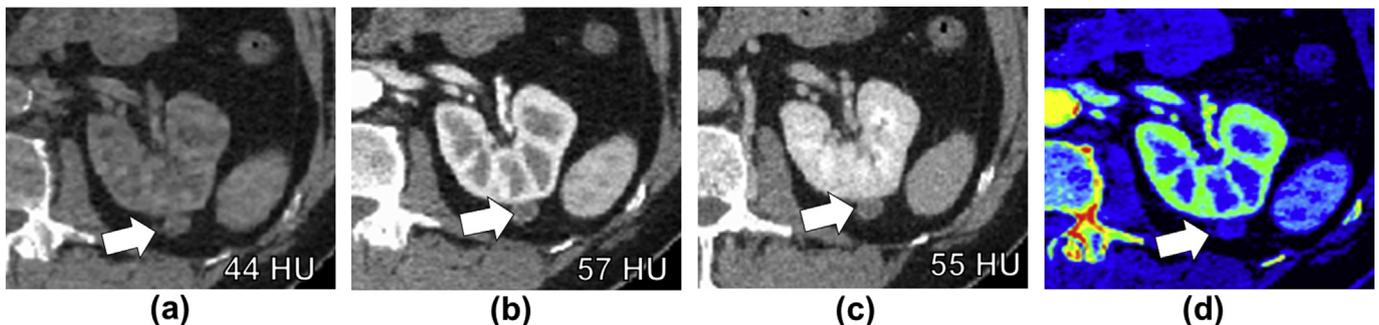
A 41-year-old woman with incidentally detected indeterminate small left renal mass on enhanced CT performed to assess for causes of abdominal pain. A DECT protocol for renal mass assessment was performed to further characterise. (a) Axial virtual unenhanced and enhanced CT images during the (b) corticomedullary and (c) nephrographic phases of enhancement depict the nodule (white arrows), which shows an increase in attenuation in the indeterminate range (between 10–20 HU difference). The nodule could be a hypo-enhancing papillary RCC or hyperattenuating cyst. (d) Colour iodine map image shows the absence of iodine within the nodule (arrow), which quantitatively measured below the previously described 2 mg/cm³ threshold for enhancement at rapid peak voltage switching DECT. The imaging findings are compatible with a hyperattenuating cyst, which was later confirmed on ultrasound (not shown).
